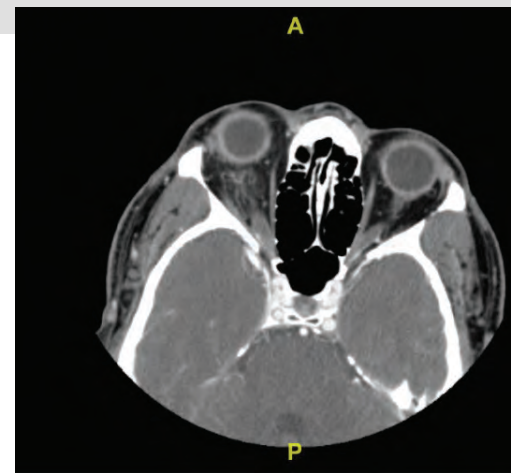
Initial CT of the orbit with IV contrast demonstrated acute right orbital cellulitis with likely superimposed posterior scleritis and optic perineuritis.
